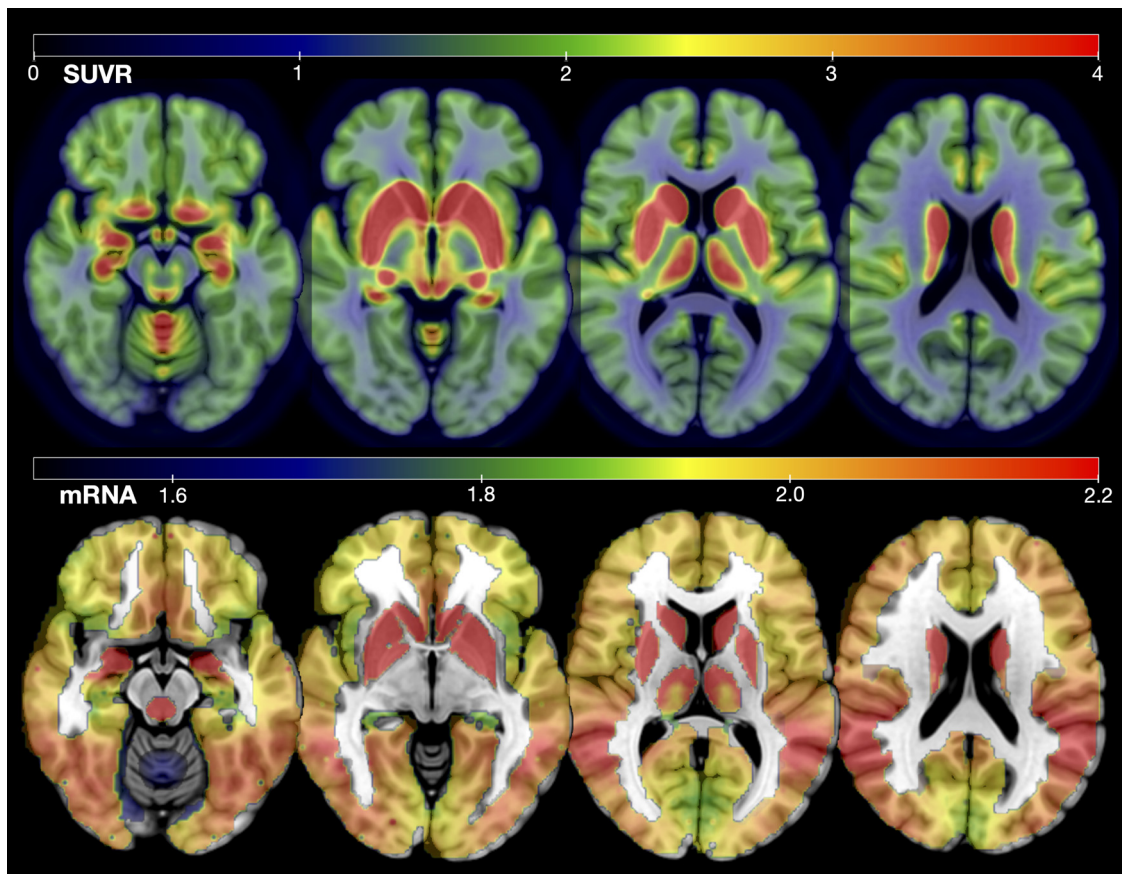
Predicted spatial distribution of *SLC18A3* (VAcHT gene) messenger ribonucleic acid (mRNA) expression levels compared to [^{18}F]FEOBV PET. The top row presents four axial slices from an average [^{18}F]FEOBV PET image generated from 20 healthy elderly subjects superimposed on the MNI space template scaled to an SUVR of 4. The bottom row shows the distribution of *SLC18A3* mRNA expression levels on the same four axial slices scaled to a value of 1.51–2.20 of log₂ mRNA expression intensity.
